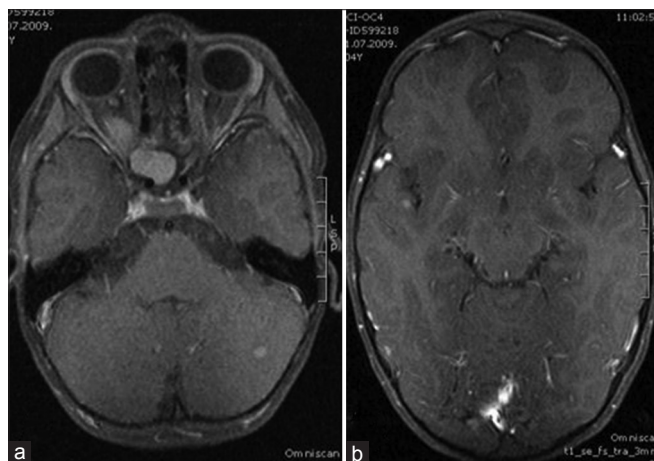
(a, b) Preoperative magnetic resonance imaging showing left cerebellar and right temporal intracranial lesions
